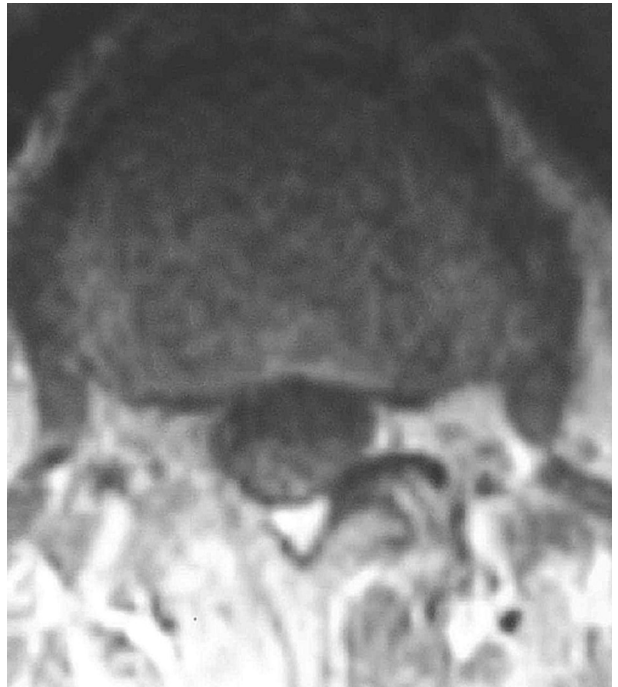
Post-operative control MRI shows no lesion or abnormal contrast enhancement.
